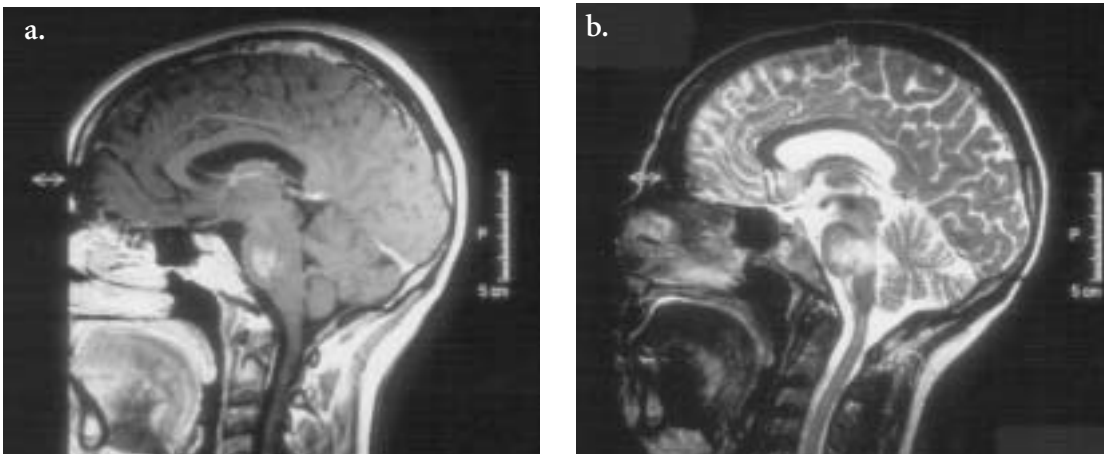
(a) T1 weighted (490ms, TE 20ms) sagittal MRI scan of brain showing an enhancing mass within the pons with high signal on T2 weighted images (TR 2000ms, TE 130ms) (b).
